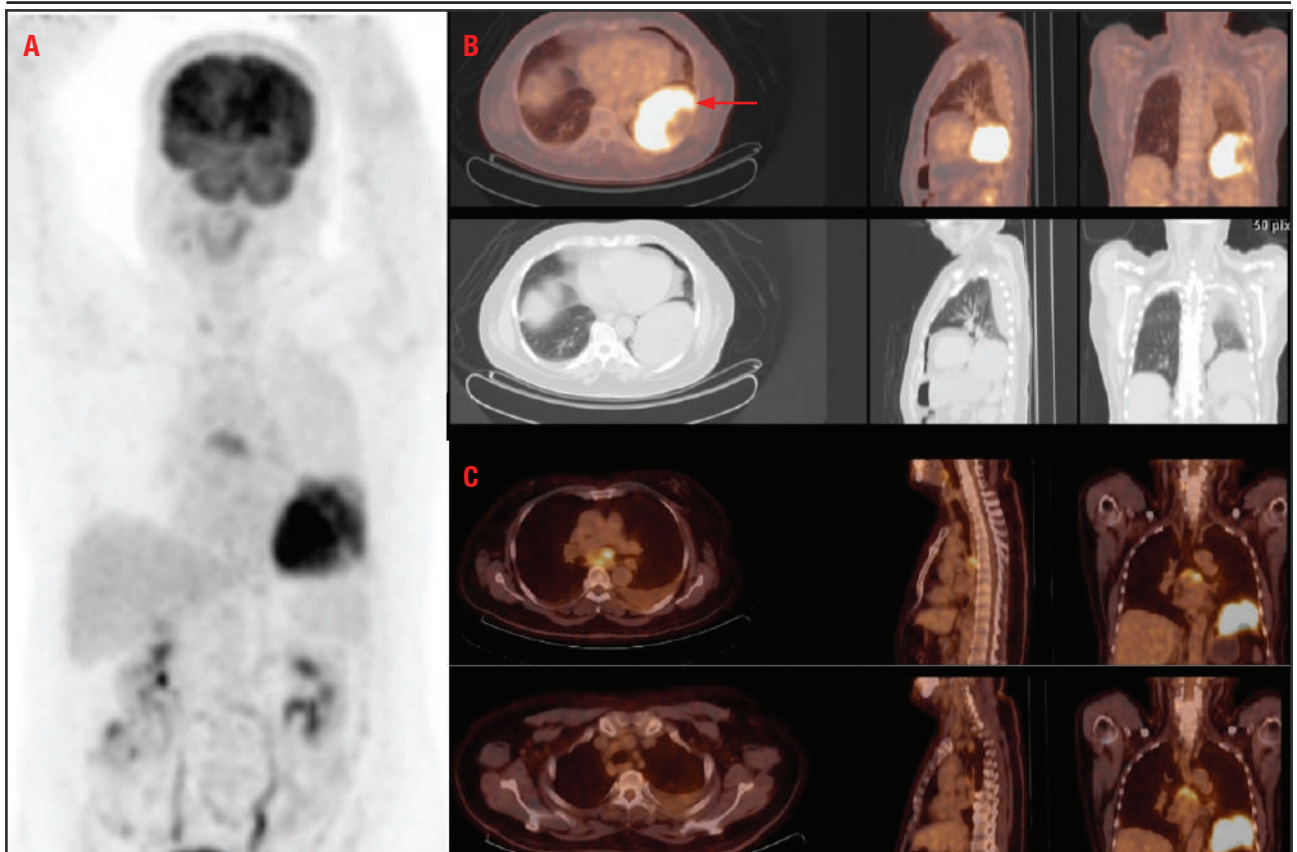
Pre-radiotherapy 18F-FDG PET/CT scan.
